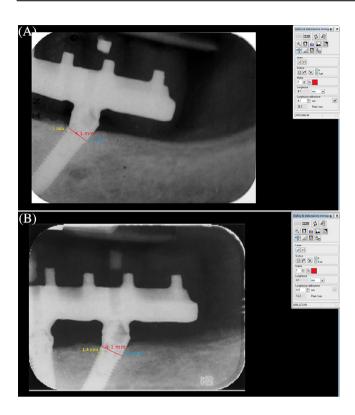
Measurement on periapical radiographs of a tilted implant: (A) baseline; (B) 5-year follow-up.
